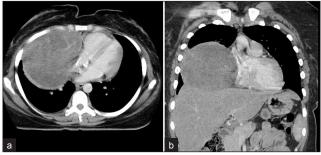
27-year-old with DFSP. (a) Axial and (b) coronal post-contrast CT images of the chest demonstrate a large round mass with mild enhancement in the right lung centered in the right middle lobe and causing mass effect on the adjacent right atrium.
